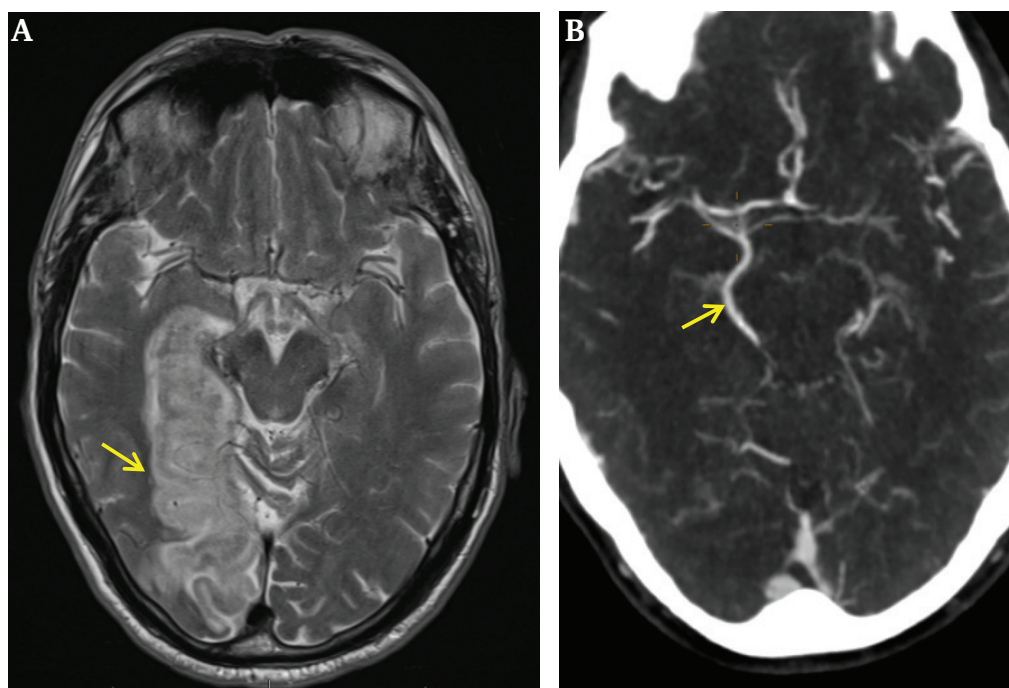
(A) Arrow showing magnetic resonance imaging of a brain with acute right posterior cerebral artery territory infarct. (B) Arrow showing computed tomography angiogram demonstrating the large right PComA.
